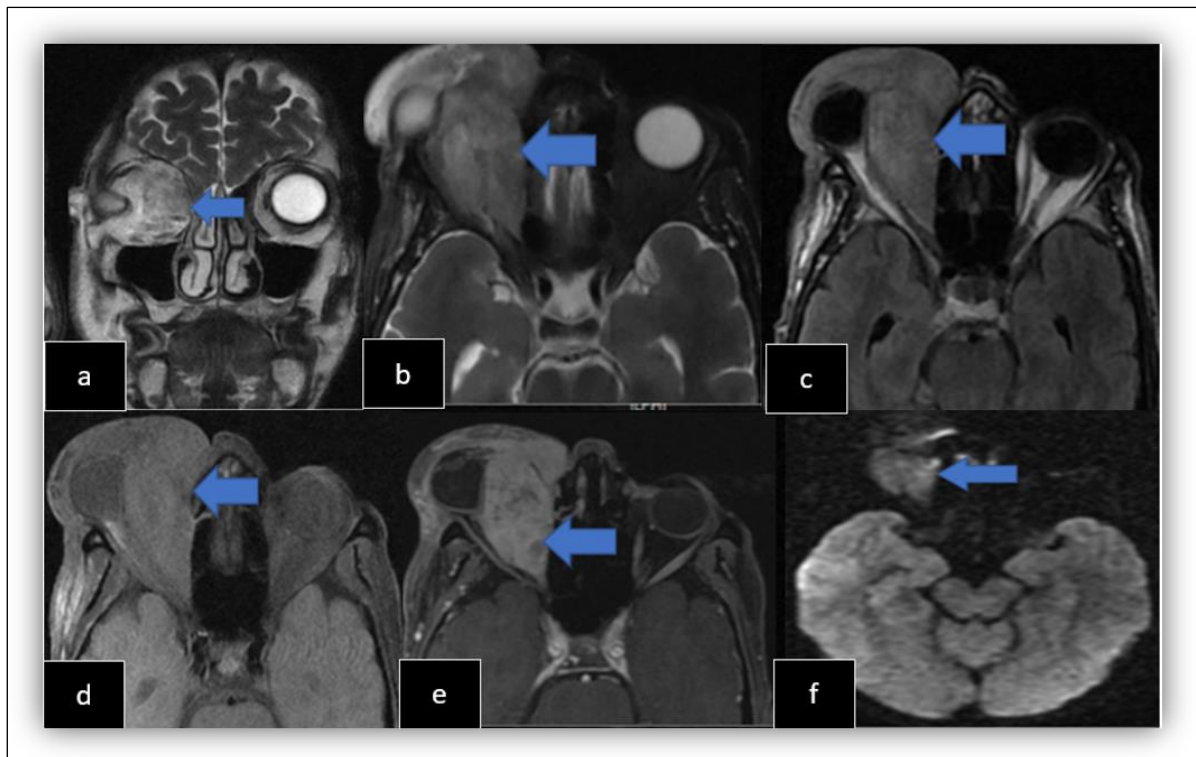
Cranio-orbital MRI shows an intraorbital and intraconal soft tissue process on the right centered on the superior oblique muscle, oval-shaped, well-circumscribed, described as heterogeneously hyperintense on T2 (arrows a, b and c), discretely heterogeneously hyperintense on T1 (arrow d), with restricted diffusion (arrow f), heterogeneously enhanced after contrast injection (arrow e), measuring $62 \times 37 \times 33$ mm in diameters (AP $\times$ T $\times$ H).
